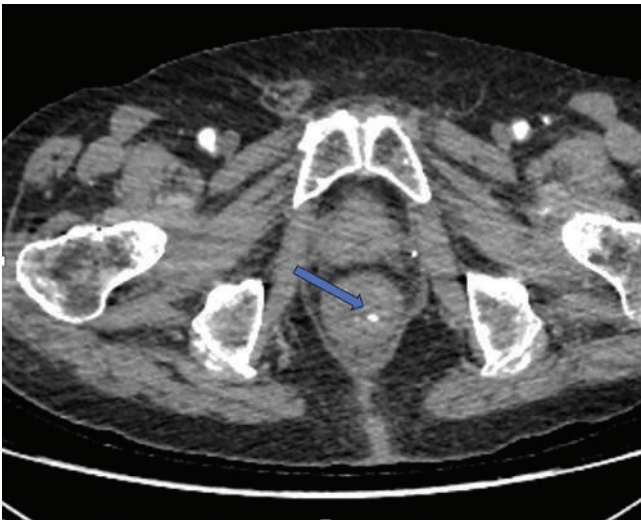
Contrast-enhanced CTA at admission. Demonstrating a 5-mm pseudoaneurysm arising from a distal branch of the left superior rectal artery (arrow), identified as the source of active lower gastrointestinal bleeding.
